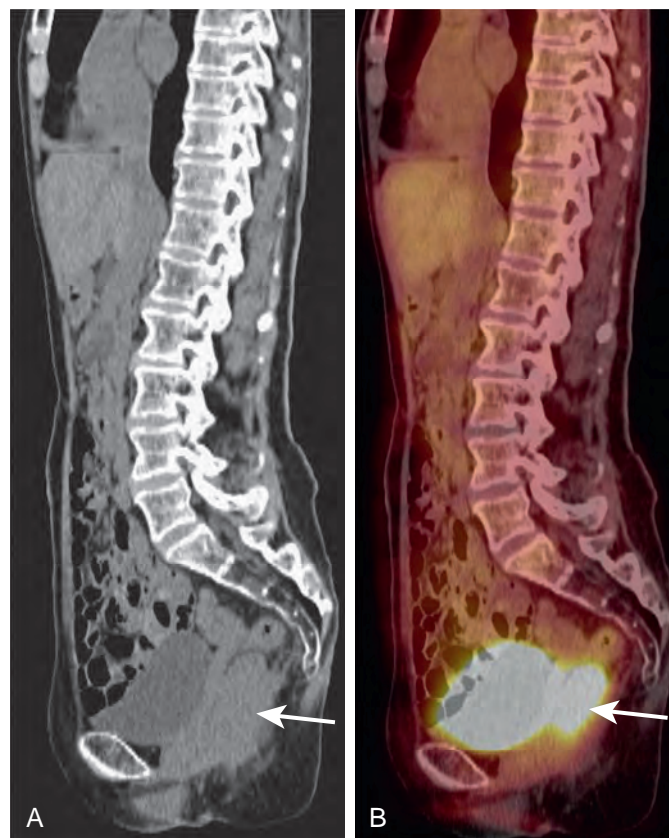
Rectal cancer. A. Sagittal non-contrast-enhanced CT scan shows a midrectal mass (arrow). B. Corresponding sagittal fused PET/CT image demonstrates intense FDG uptake in the mass (arrow).
